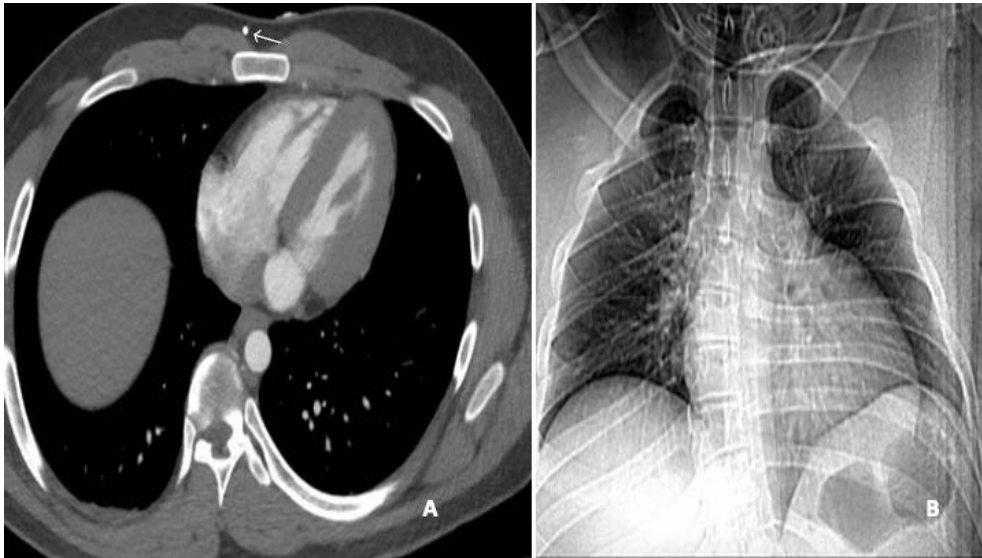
Follow-up images demonstrating appropriate positioning of the right VP shunt and new left VA shunt without complications. Postoperative chest CTA (A) and chest radiograph (B) with no evidence of residual catheter within the heart or main pulmonary arteries.
